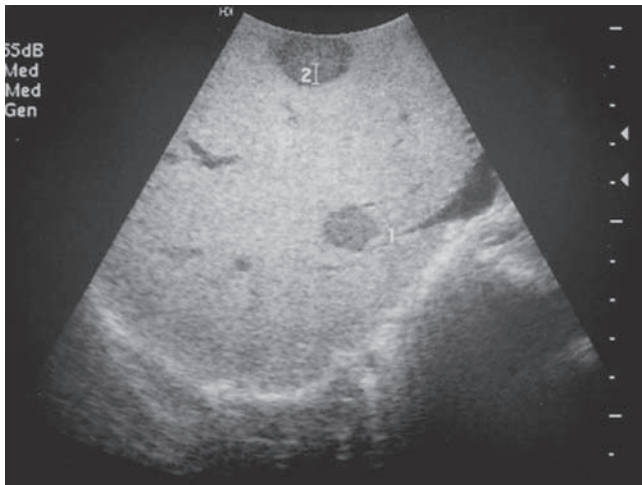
Intraoperative ultrasonography for the operative assessment of hepatic colorectal metastases. A. Image of a metastasis detected intraoperatively. B. Sensitivity of IOUS depends on the echogenicity of the known (index) lesions. (van Vledder MG, Pawlik TM, Munireddy S, Hamper U, de Jong MC, Choti MA. Factors determining the sensitivity of intraoperative ultrasonography in detecting colorectal liver metastases in the modern era. *Ann Surg Oncol.* 2010 Oct;17[10]:2756–2763.)
